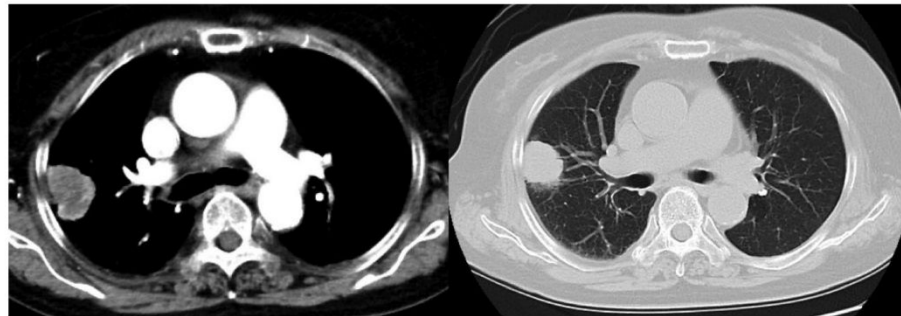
Chest computed tomography shows a 55 × 35 mm tumor in the right upper lobe.
